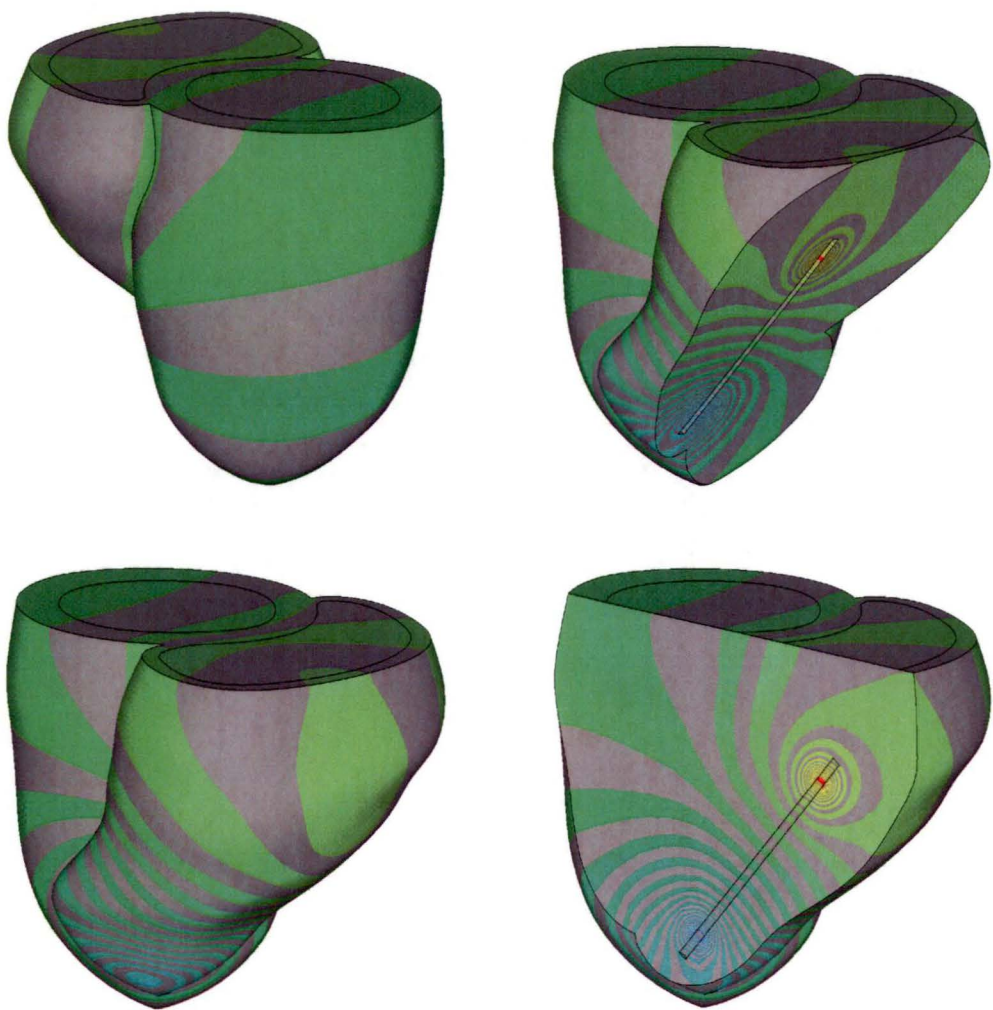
Right ventricle catheter voltage contours in tagged MRI model at end diastole for blood conductivity/myocardium conductivity = 2.75.
